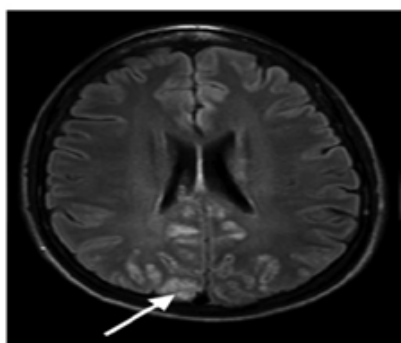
Magnetic resonance image of axial section brain showing foci of FLAIR increased intensity in bilateral parietal and occipital regions.
